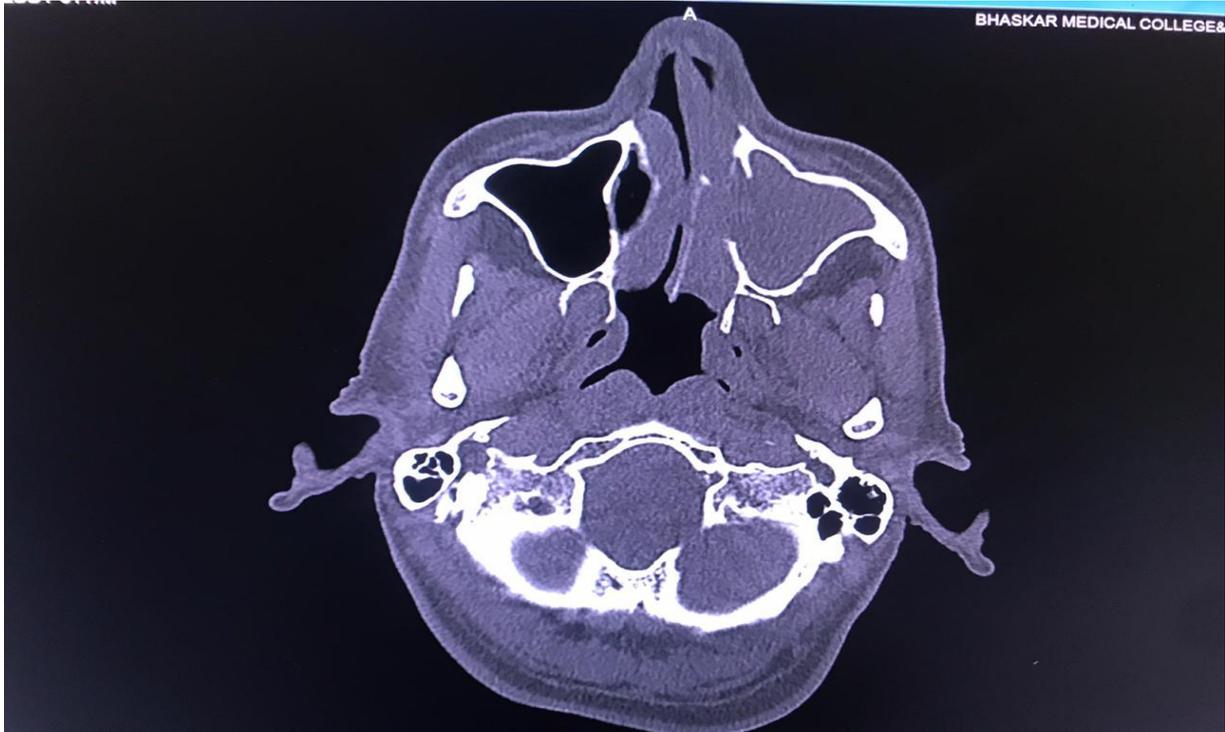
Axial and Coronal sections of CT PNS showing Antro-choanal polyp - soft tissue density lesion in the left maxillary sinus extending through widened OMC into the nasal cavity. Note also DNS to the left.
